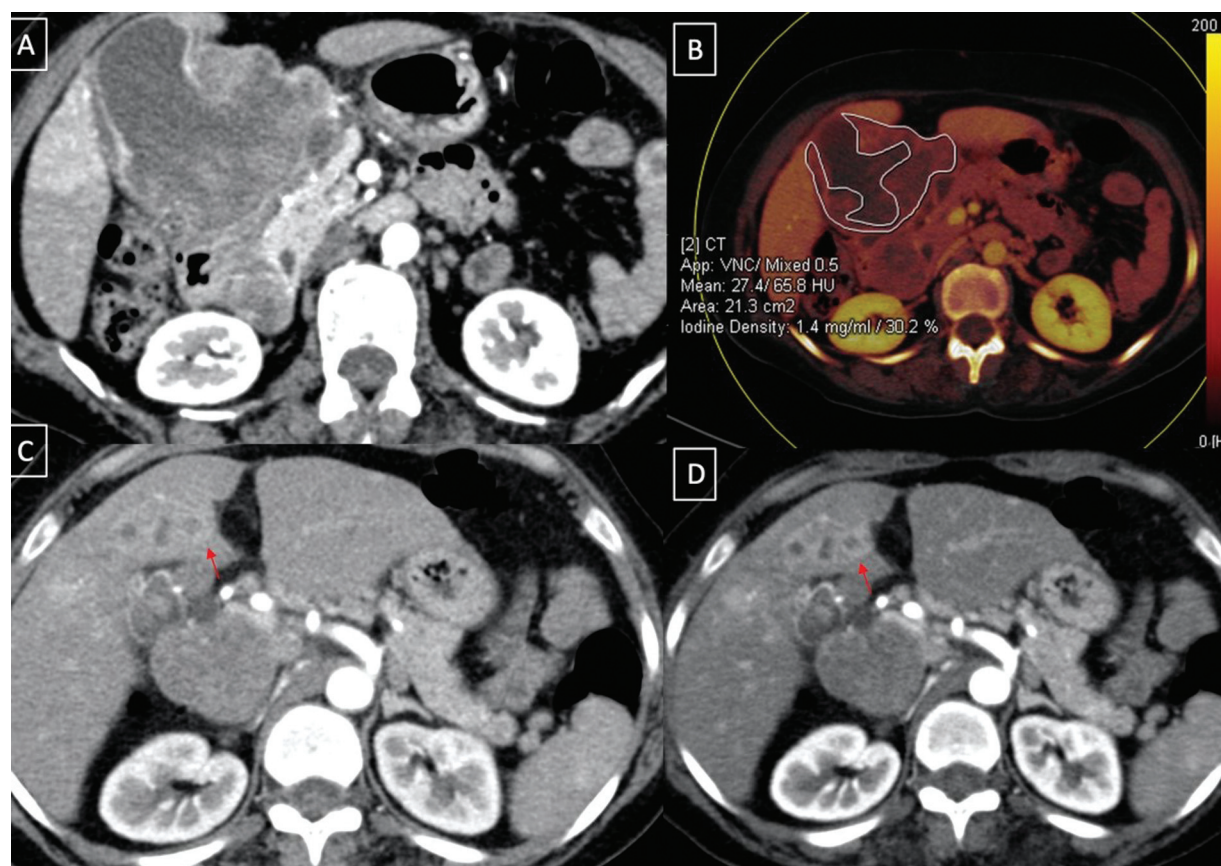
Dual-energy computed tomography for malignant gallbladder mass. Axial images (A, B) show the heterogeneously enhancing gallbladder mass with increased iodine uptake. The discrete liver lesions were less conspicuous on higher energy (140 keV) image as compared to lower energy (80 keV) image which has a higher contrast resolution.
